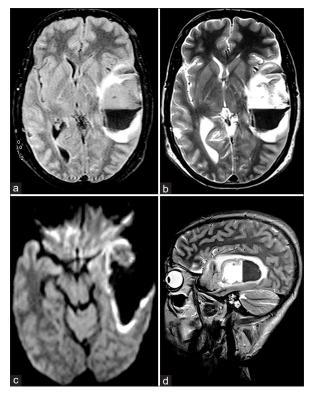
Resolving intracerebral hemorrhage in left temporal lobe seen on (a) axial FLAIR imaging, (b) axial T2-weighted image, (c) axial diffusion-weighted imaging, and (d) left parasagittal T2-weighted imaging
